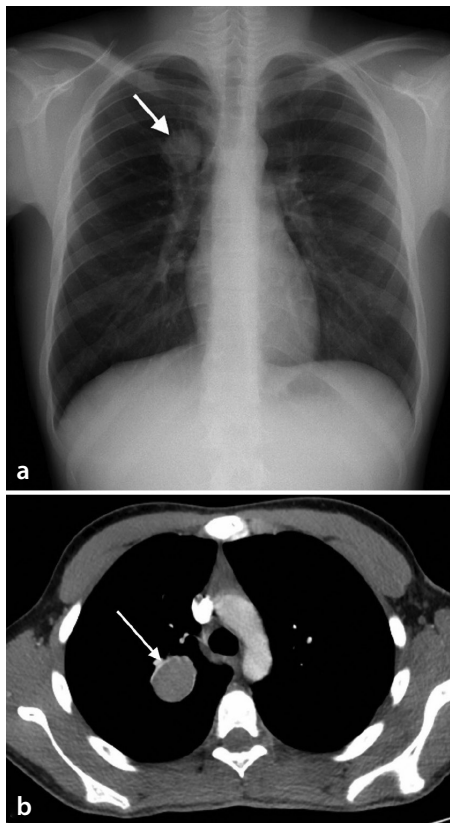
(a, b) A 16-year-old boy with lymphoepithelioma-like carcinoma. (a) The chest X-ray taken prior to the orthopedic surgery shows a nodule with smooth contours (arrow). (b) The axial contrast-enhanced chest computed tomography scan shows a uniform mass lesion (arrow).
